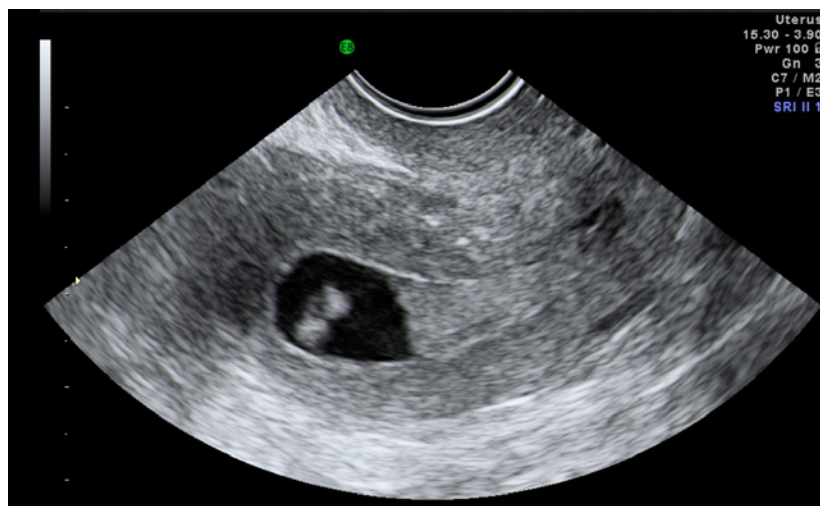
Ultrasound showing thickened endometrial cavity with fluid
